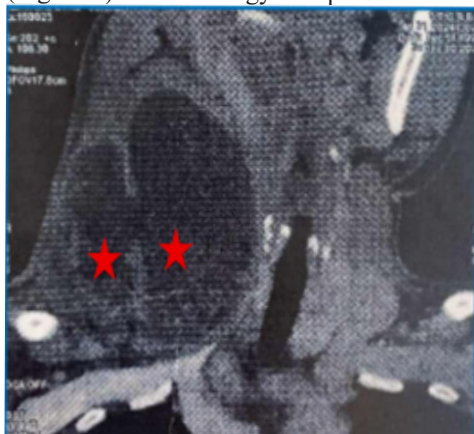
Contrast-enhanced cervico-thoracic CT scan
